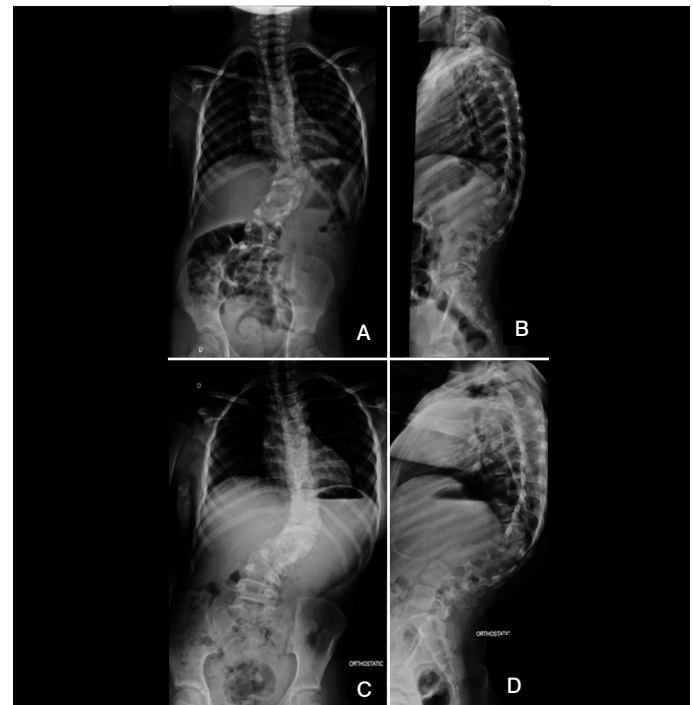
Radiographic progression of congenital scoliosis, between the initial consultation in February 2018 (A and B) and the last consultation in March 2023 (C and D).
